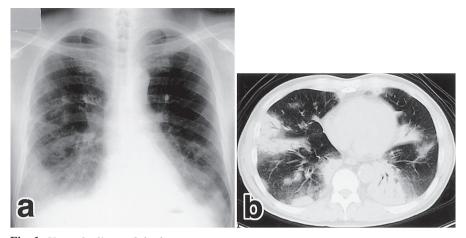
X-ray findings of the lung.
